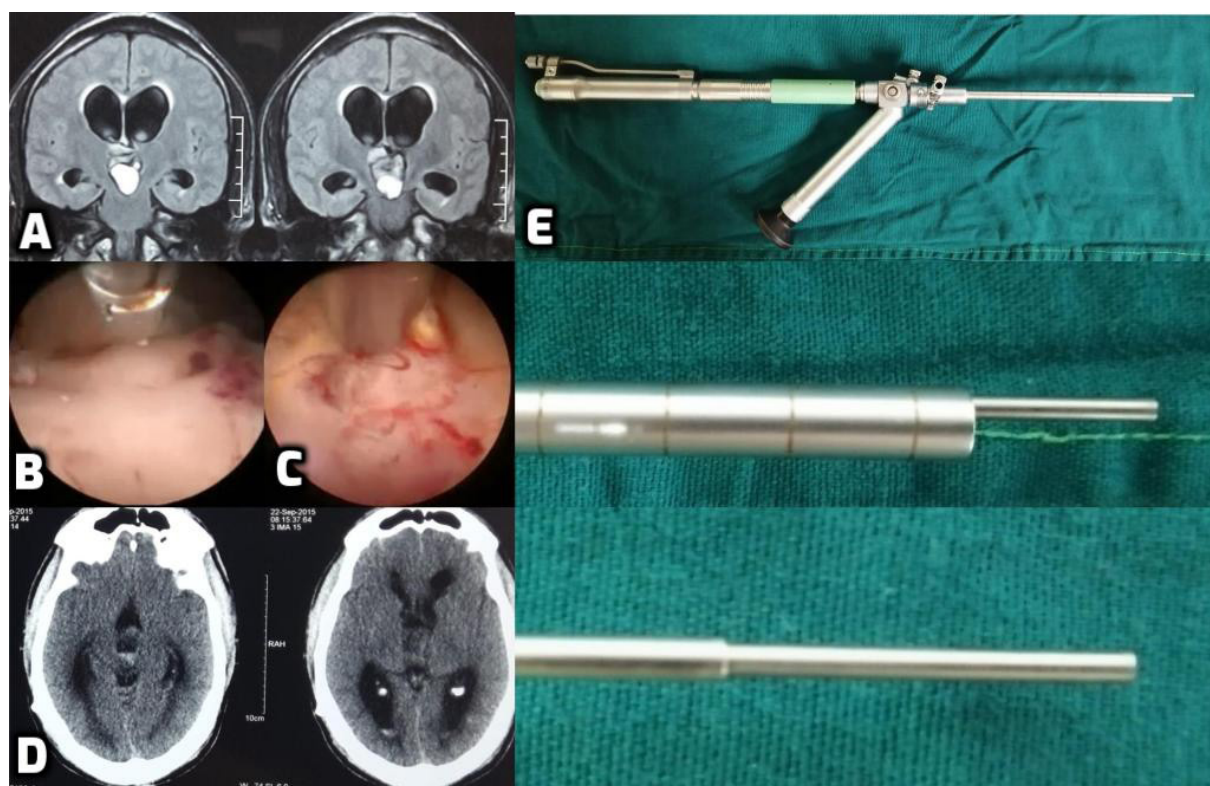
A: MRI FLAIR coronal section of an intraventricular solid cystic pilocytic astrocytoma; B: endoscopic view of the tumour; C: ultrasonic surgical aspirator applied for excision of the lesion; D: postoperative CT scan after gross resection of the lesion via endoscopic approach; E: ultrasonic surgical aspirator instrument with zoomed image of the tip
